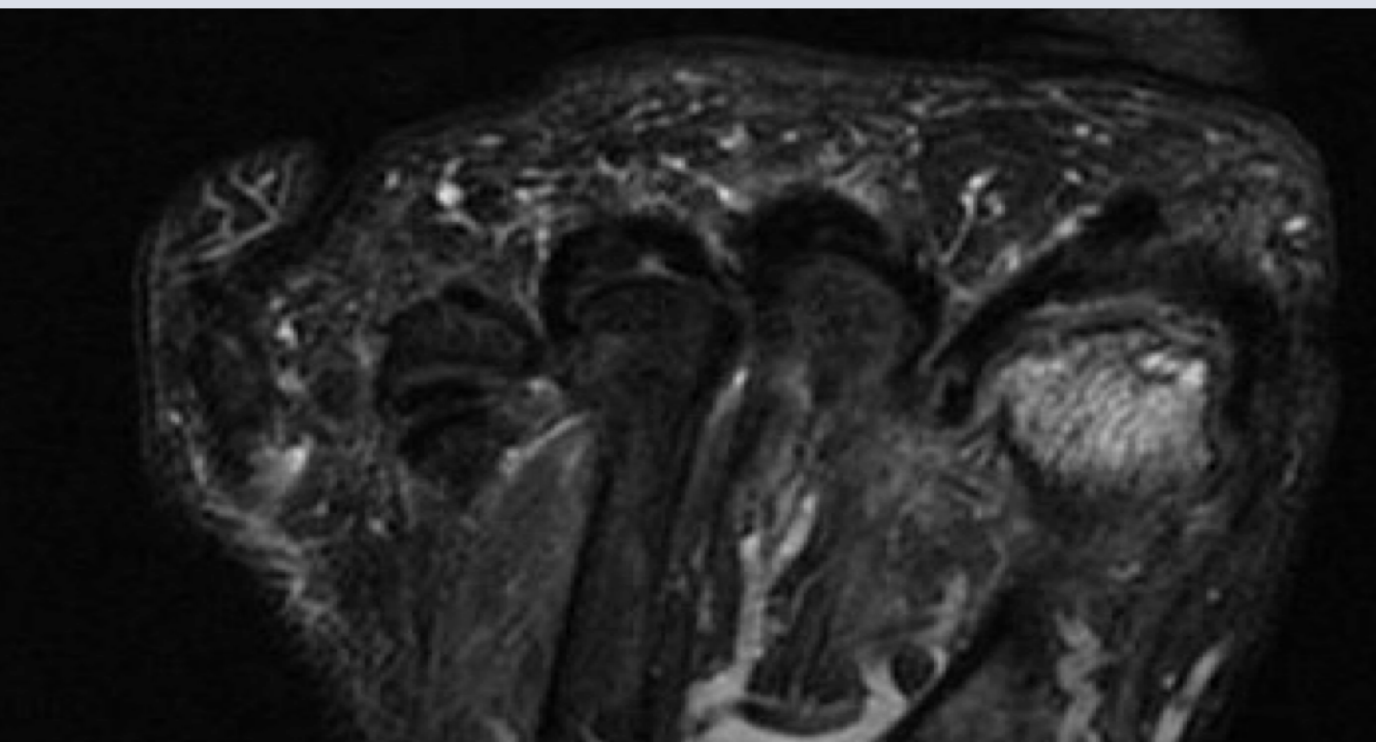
MRI follow up on patient 1, 7 months from original surgery
